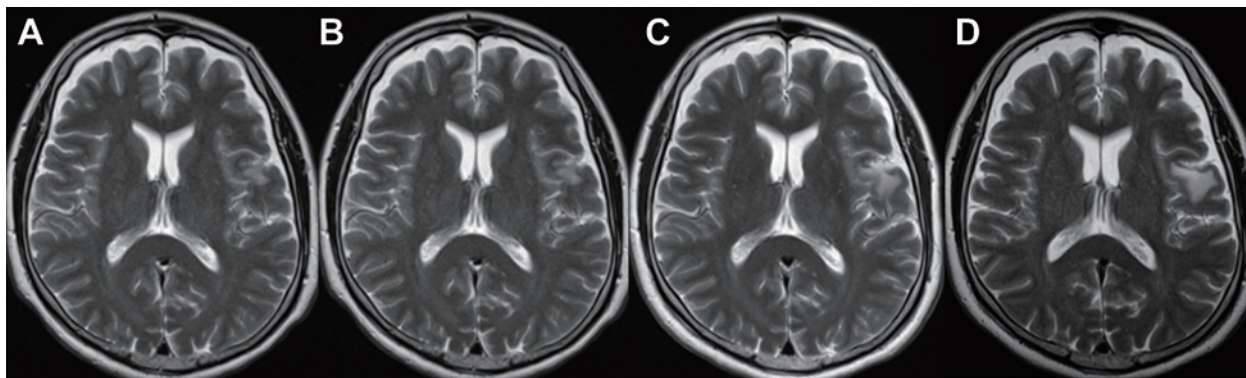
Sequential magnetic resonance imaging (MRI) at initial diagnosis and before tumor resection. T2-weighted MRI images: 8 years before (A), 6 years before (B), 2 years before (C), and immediately before surgery (D). The peritumoral edema showed gradual development concurrent with the slow growth of the tumor.
